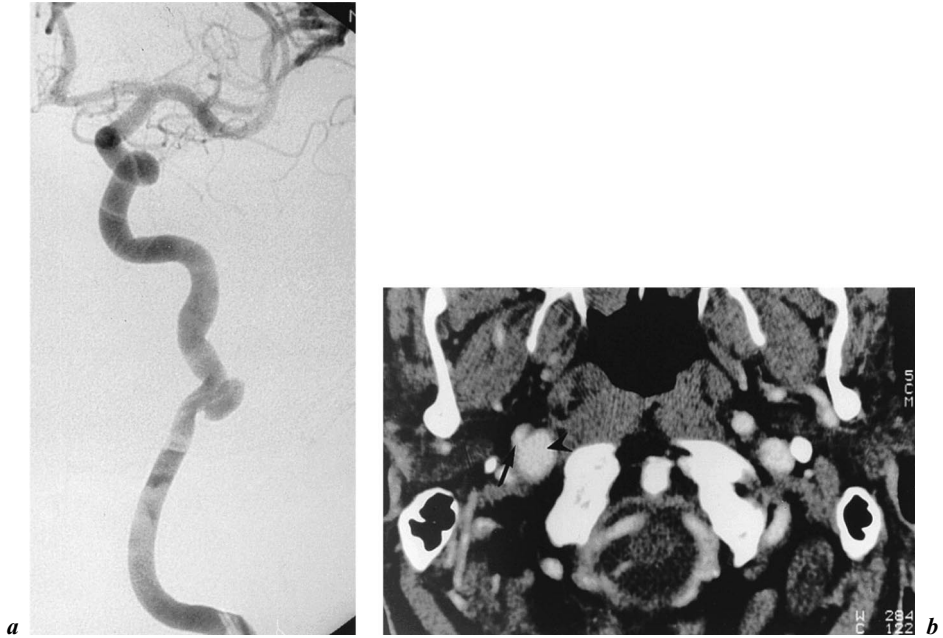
a* Internal carotid artery (ICA) dissection with aneurysm at the upper portion of the right ICA on angiography. *b* Helical CT findings showing both narrowed eccentric lumen (arrow) and aneurysm (arrowhead).
